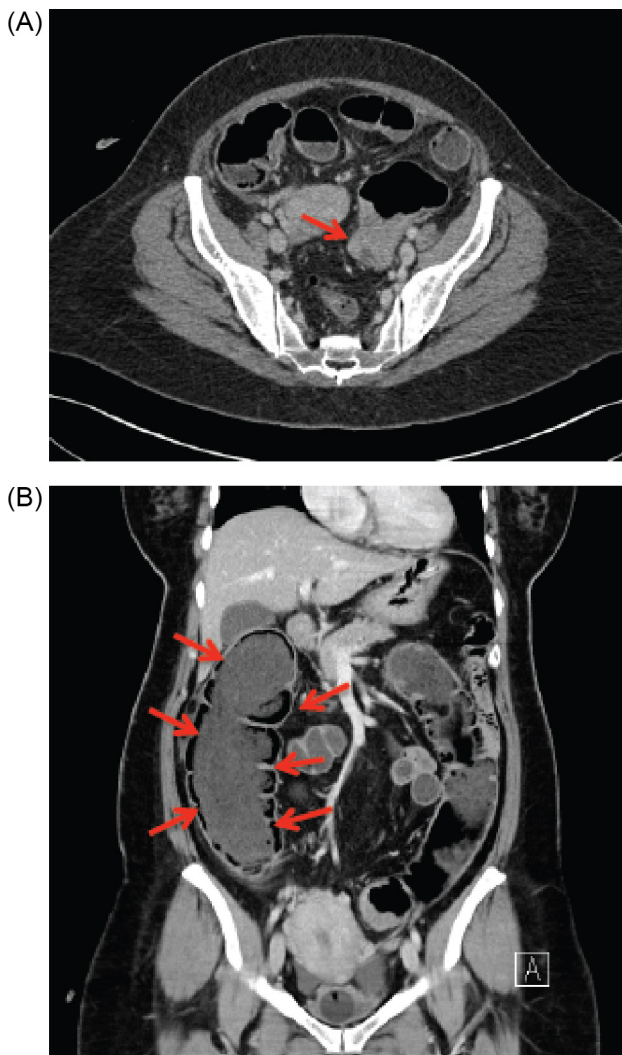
Computed tomography of abdomen. A: Abdominal computed tomography showed the segment of thickening wall at sigmoid colon with nearly obstruction (red arrow); B: Intramural gas along the colonic mucosa in cecum and ascending colon was seen (red arrows).
